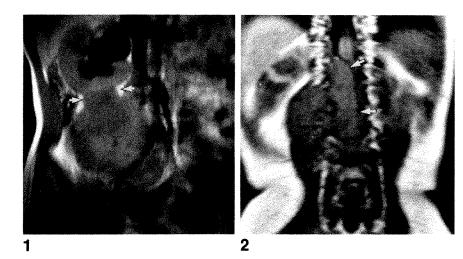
7-year-old girl with Wilms tumor. Coronal SE T1-weighted image (500/18) depicts exophytic nature of tumor, which arises from lower pole of right kidney (arrows) and causes hydronephrosis due to compression of distal ureter.
